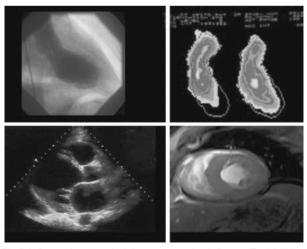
Commonly used methods for assessing cardiac dysfunction. Top left: LV contrast angiogram. Top right: radionuclide ventriculogram/MUGA. Bottom left: 2D echocardiogram. Bottom right: CMR scan.
